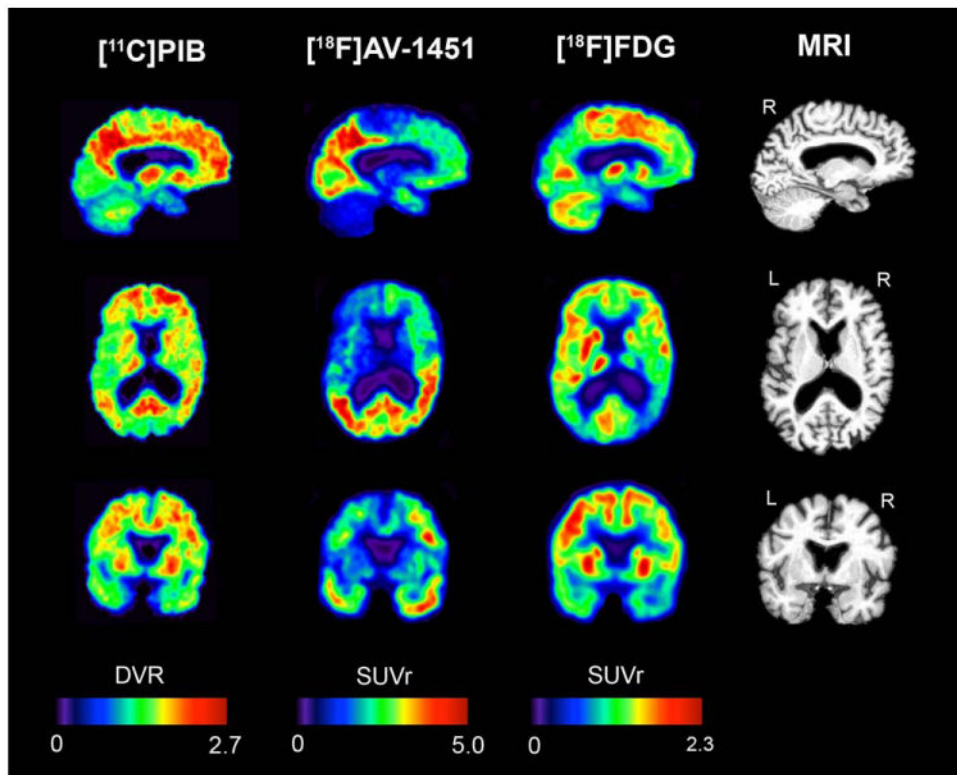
Sagittal, axial, and coronal slices of [^{11}C]Pittsburgh compound B (PIB), [^{18}F]AV-1451, and [^{18}F]fluorodeoxyglucose (FDG) positron emission tomography alongside structural magnetic resonance imaging (MRI) scan. DVR = distribution volume ratio; L = left; R = right; SUVR = standardized uptake value ratio
